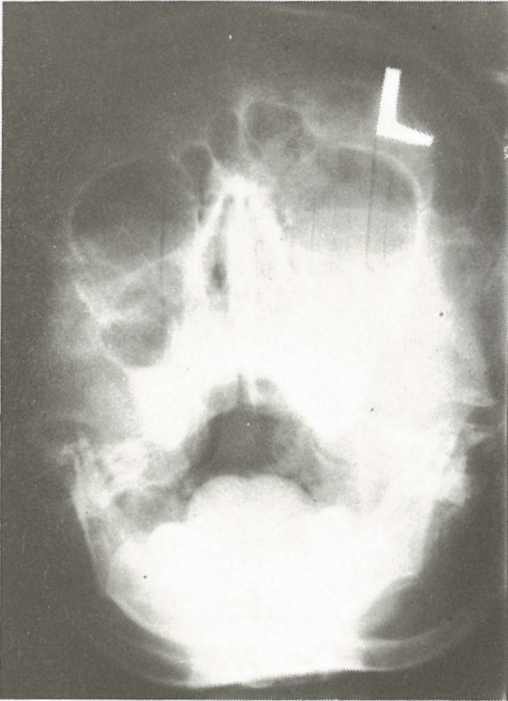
X-ray finding: diffusely shaded left maxillary sinus
